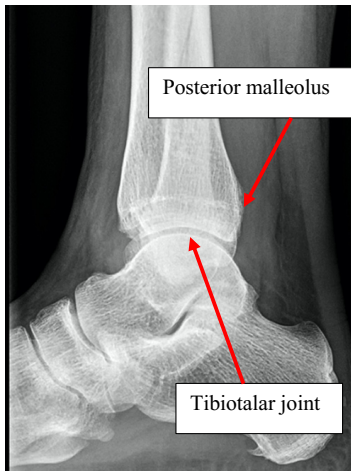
Lateral radiograph of the ankle joint
